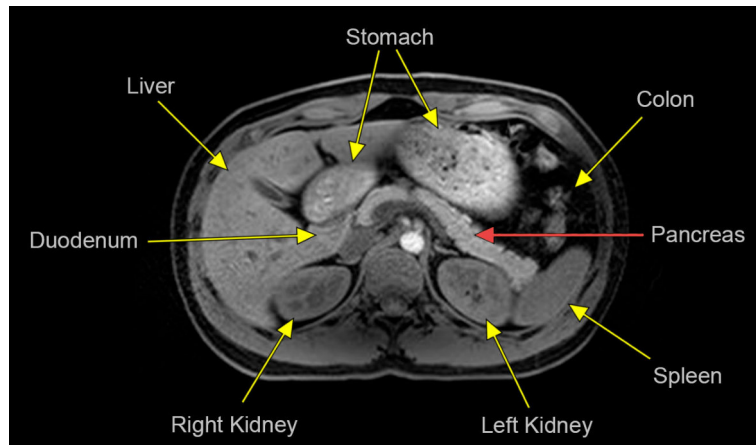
Transverse T_1 weighted MR image showing the pancreas (red arrow) in close proximity to several organs (yellow arrows), which limit the possible dose to a target volume in PDAC.
